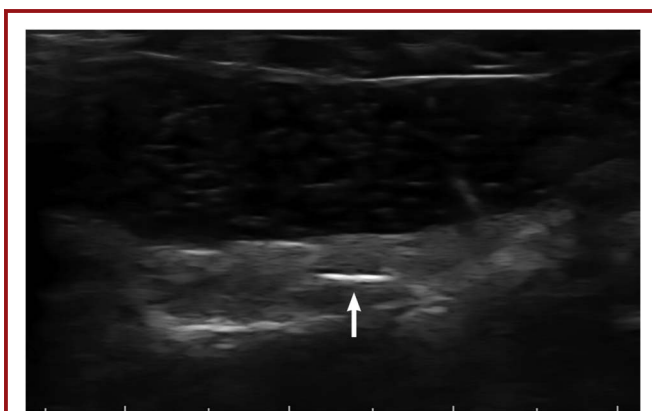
After implantation of the scaffold, intraoperative sagittal ultrasonography was performed. Note the hyperechoic scaffold (arrow) within the surrounding spinal cord parenchyma. Used with permission from InVivo Therapeutics Holdings, Corp.
